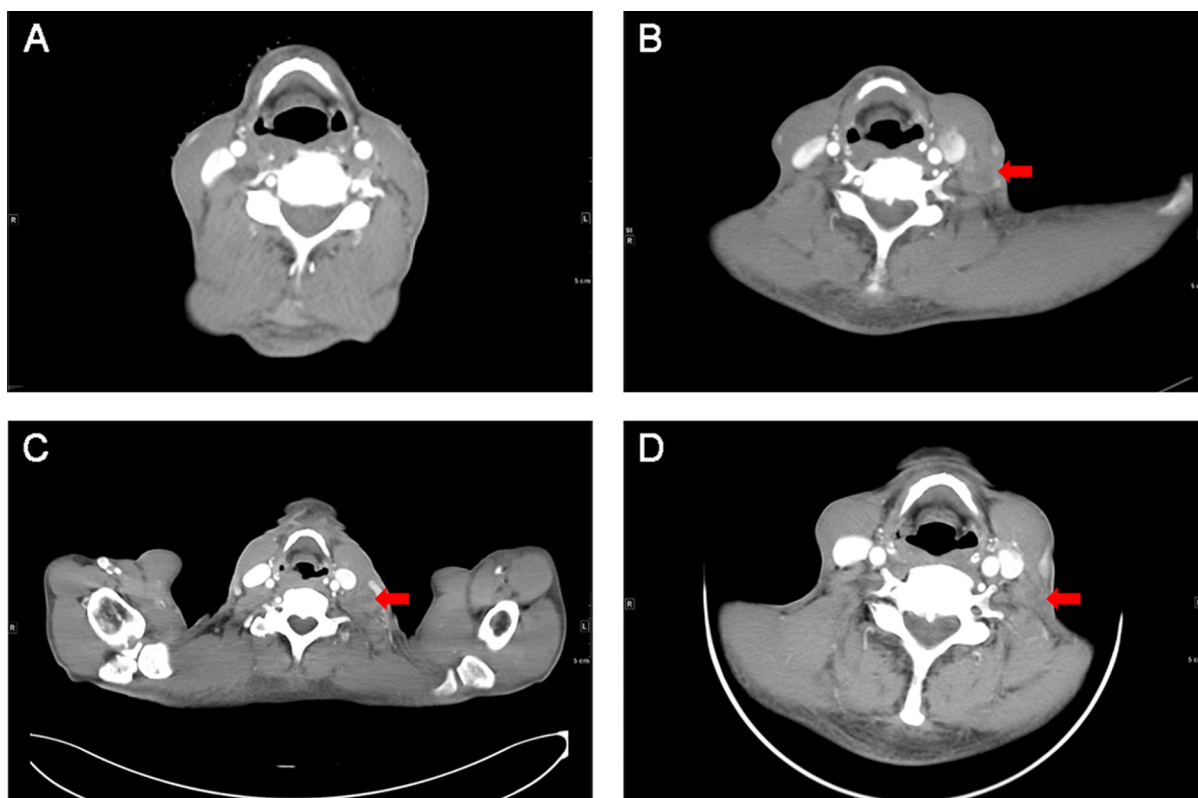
Cervical CT showed no lymphadenopathy before surgery (A); CT showed a significantly enlarged lymph node in the left neck which prompted PD after first-line chemotherapy (B); CT revealed the left cervical lymph node was not reduced after radiotherapy and irinotecan treatment (C); CT examination showed the swollen lymph nodes significantly narrowed and the border was not clear, suggesting that the patient achieved PR (D).
